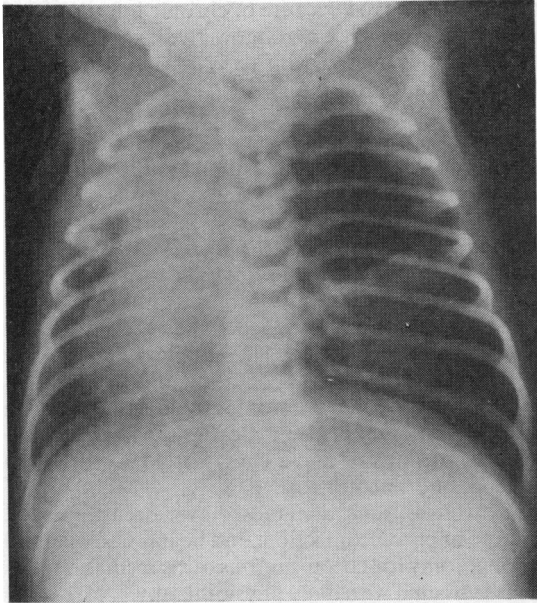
(Case 1.) Chest x-ray film at 24 hours showing situs inversus and patchy shadowing in the right upper zone and left middle and lower zones.
